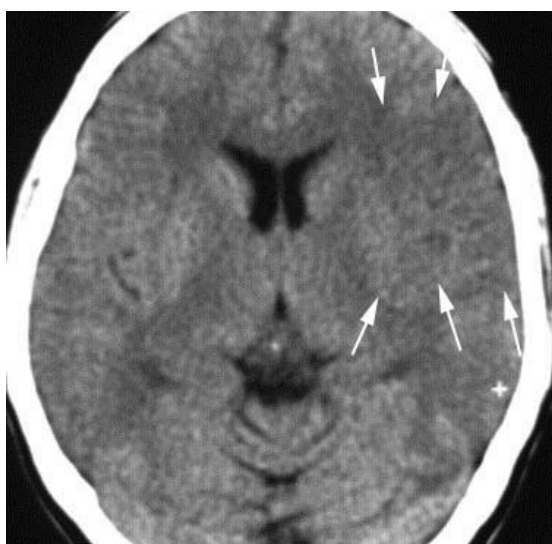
CT in a 37-year-old woman obtained 0.5 h after the onset of aphasia and right hemiparesis witnessed by her husband. The arrows indicate an area with subtle hypo-attenuating brain tissue.
